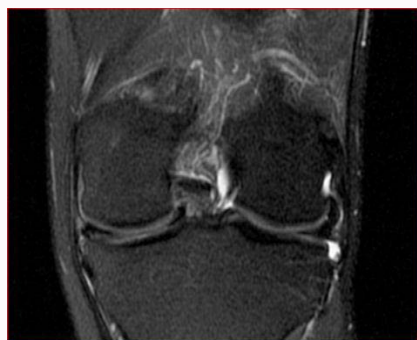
Preoperative MRI frontal scan of the right knee showing a bucket handle tear of the medial meniscus.
